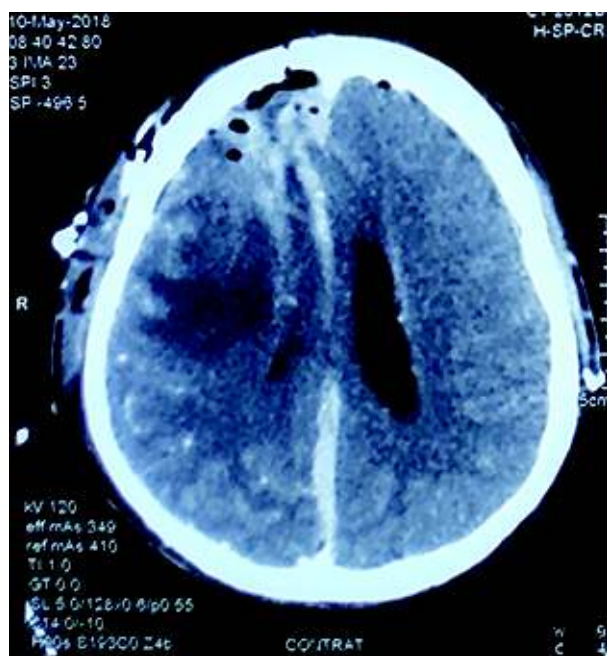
Contrast CT scan showing residual lesion .
